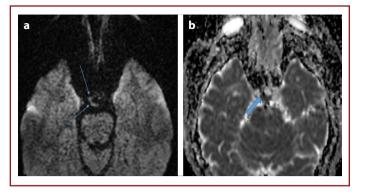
(a) Images showing peripheral diffusion restriction on the same lesion on DWI- B1000 (Thin arrows). (b) ADC (Apparent Diffusion Coefficient) (Thick arrow).
